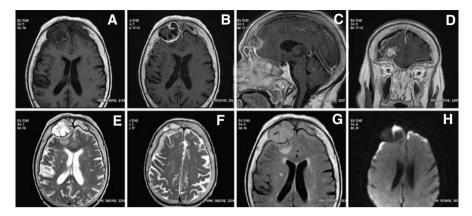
MRI study of a patient with frontal mucopyocele complicated with intracranial infection. T1 (A) and contrast-enhanced T1 weighted images (B–D) demonstrate a small subdural hypointense collection surrounded by fine contrast enhancement. This collection appears hyperintense on T2 weighted (E, F) and FLAIR images (G) and shows restricted diffusion (H). These findings were diagnostic of subdural empyema that was operated on with positive cultures for *Streptococcus milleri*
